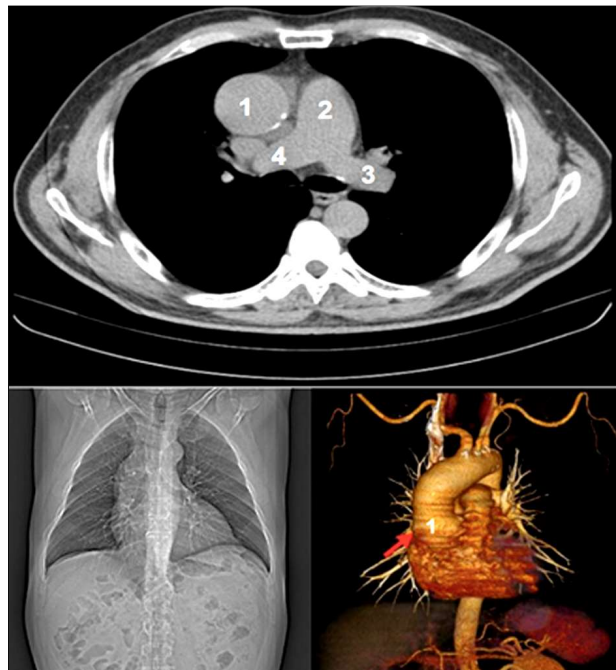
CT (Computed Tomography) angiography: Dilation on the ascending aorta: 1- Aortic aneurysm, 2-Descending aorta, 3-Left pulmonary artery, 4- Right pulmonary artery.
